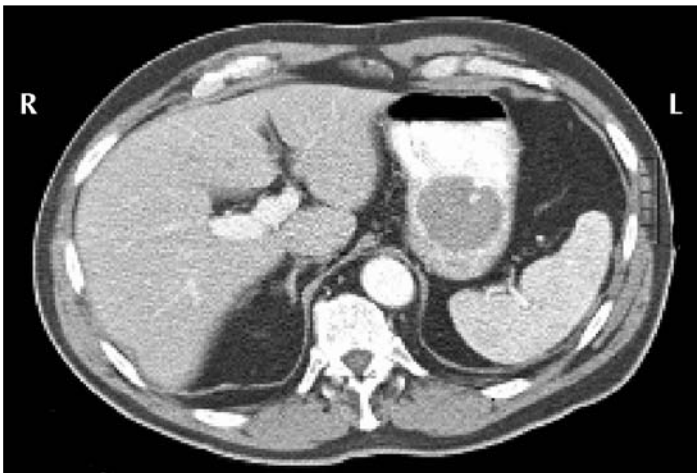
Computed tomographic scan of the abdomen with oral contrast revealing the lesion in the stomach.
